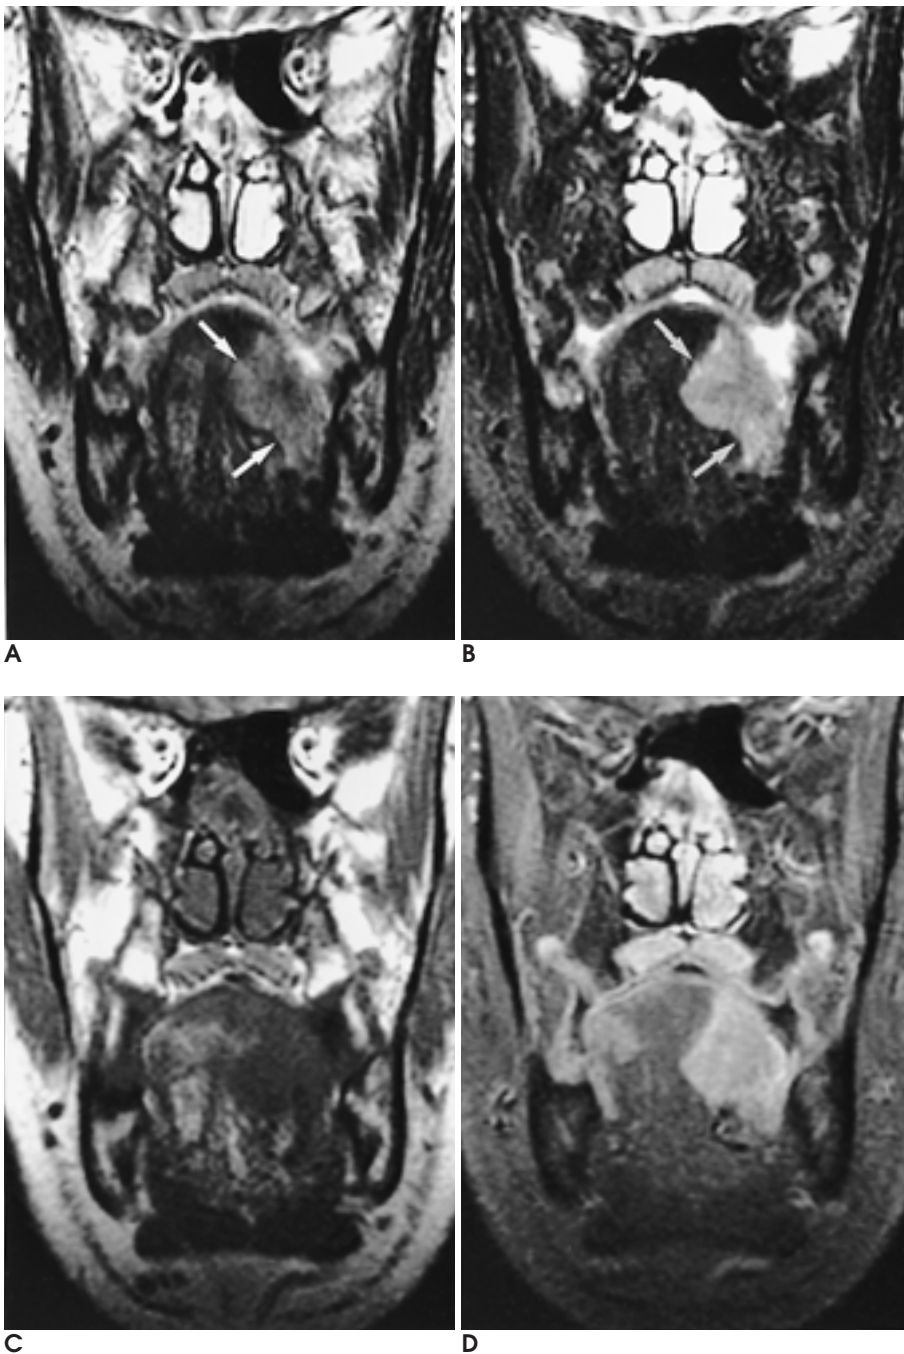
Case 4. A 49-year-old man with tongue cancer. Coronal fast spin-echo T2-weighted image (A) shows a slightly hyperintense mass (arrows) at the left side of the mobile tongue. Coronal fat suppressed fast spin-echo T2-weighted image (B) demonstrates improved conspicuity of the tumor (arrows) and suppression of fat signals from the intact areas of the tongue. The tumor is isointense on T1-weighted image (C) and is homogeneously enhanced on fat suppressed T1-weighted image (D).
